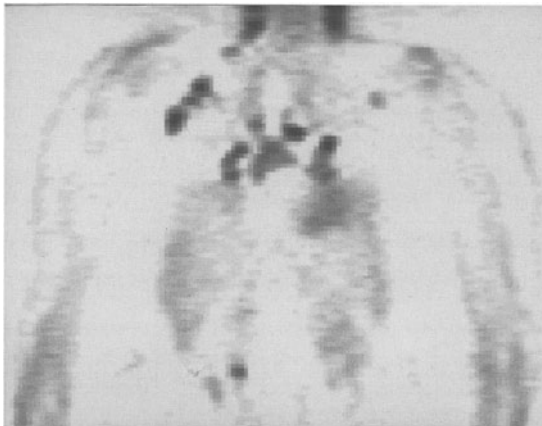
A ^{18}F FDG PET study in a patient with pulmonary sarcoidosis. The coronal cut shows uptake in the mediastinum, hila, axillary and supraclavicular lymph nodes.*
